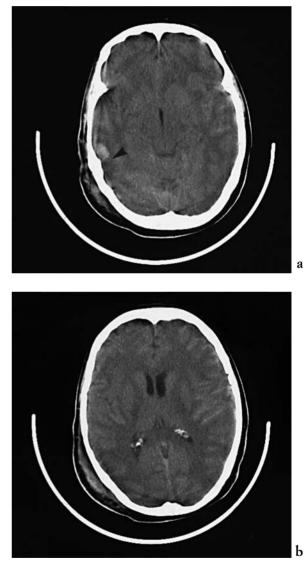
Subarachnoid haemorrhage. Hyperdensity is noted within the cortical sulci over the left cerebral hemisphere. Small haemorrhagic cortical contusions are also seen, the largest of which can be observed in the right temporal region (arrowhead). [a), b) axial CT].
